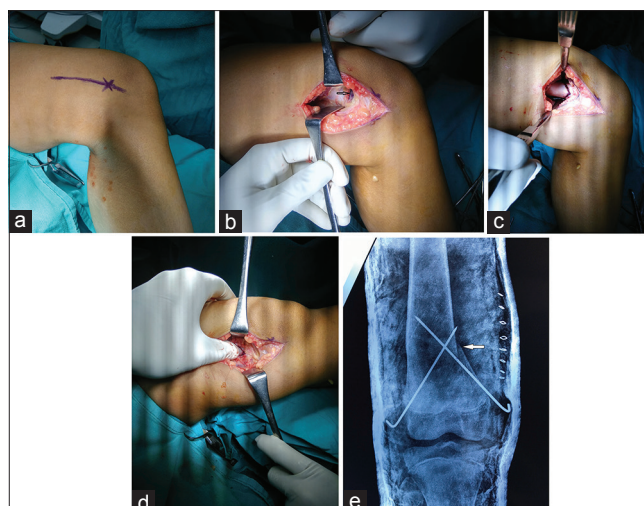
(a) Showing planned incision. X = adductor tubercle. (b) Exposure of distal femur after lifting vastus medialis anterior. Arrow shows epiphyseal vessels crossing transverse in the distal femur. (c) Showing planned osteotomy proximal to epiphyseal vessels. It is to be noted that anterior limb of the osteotomy is longer than the posterior. (d) Intraoperative picture showing how telescoping of proximal medial cortex was done in distal medial cortex with the help of thumb. (e) Immediate postoperative anteroposterior radiograph of knee showing osteotomy and its fixation with two cross K-wires. Arrow shows telescoping of proximal fragment into distal fragment
